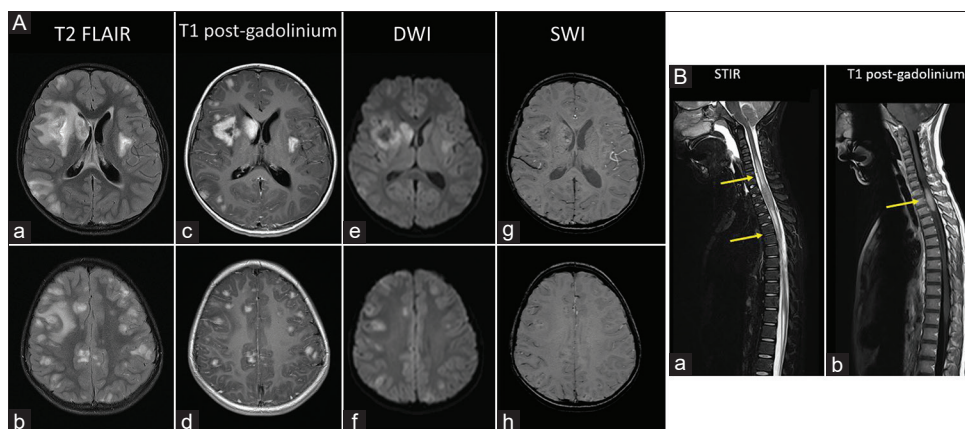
(A) Brain T2 FLAIR demonstrating multifocal hyperintense bilateral, patchy lesions (a and b) with contrast enhancement (c and d). Restricted diffusion is noted in some of these lesions (e and f) as well as hemorrhagic changes are noted in SWI (g and h). FLAIR: fluid-attenuated inversion recovery; DWI: diffusion-weighted magnetic resonance imaging; SWI: susceptibility weighted imaging. (B) Large confluent lesions extending the entire spinal cord and revealing longitudinally extensive myelitis (a) with an intensely enhancing, expansile intramedullary lesion from T1 to T3 (b). STIR: short-tau inversion recovery
